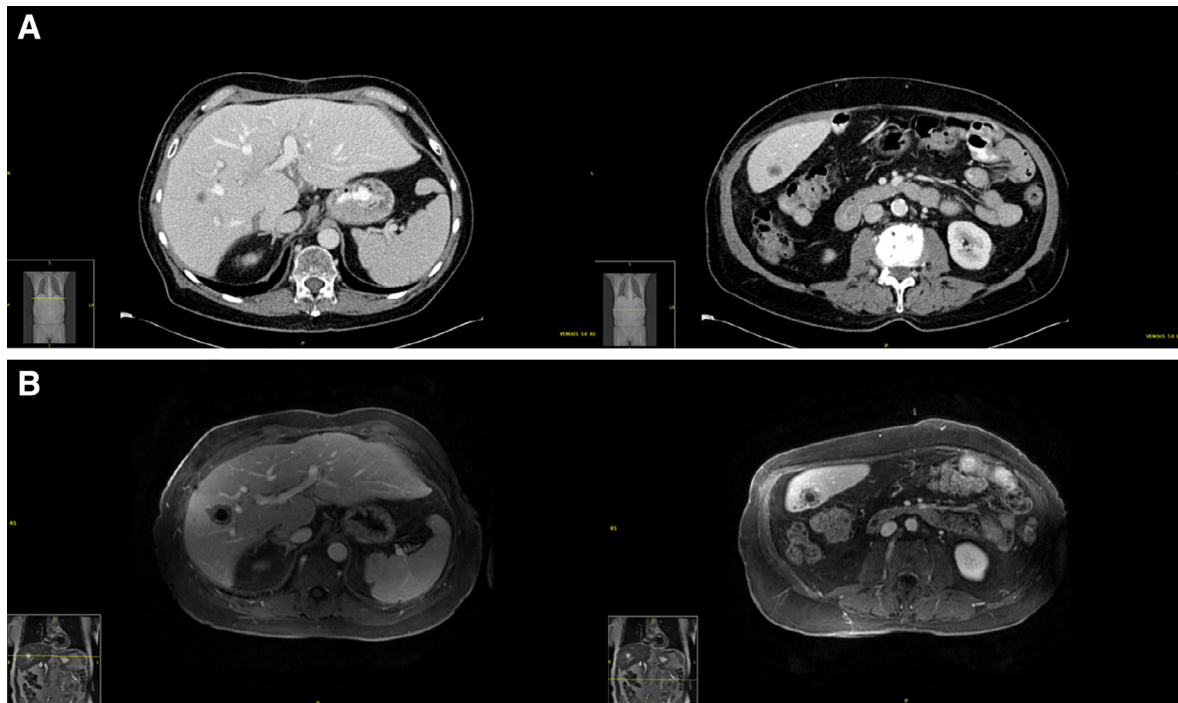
Imaging showing progression of the lesions over time. (A): Computerized tomography scan of the abdomen showing two of the three liver lesions found on follow-up scans 4 months after transplantation. (B): Magnetic resonance imaging of abdomen showing the progression of the two liver lesions seen before with progression after a period of 6 weeks of observation.
